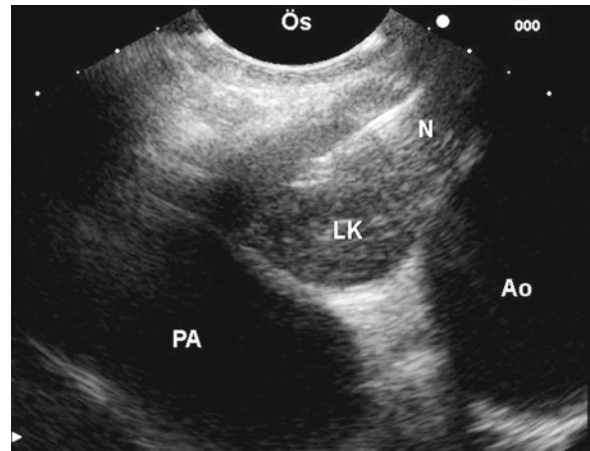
(a) Computed tomography of the thorax. Right upper-lobe tumor (*T*) and enlarged subcarinal lymph node (*LK*). (b) Endosonography. Sonography-guided fine-needle aspiration (*N* needle) of a hypoechoic lymph node with sharp borders located between the esophagus (*Ös*), pulmonary artery (*PA*) and left atrium (*LV*) (lymph node station 7). (c) Cytology. Fine-needle aspirate demonstrating adenocarcinoma with vacuoles and enlarged central nuclei. Squamous cells from the esophagus can be recognized on the left
